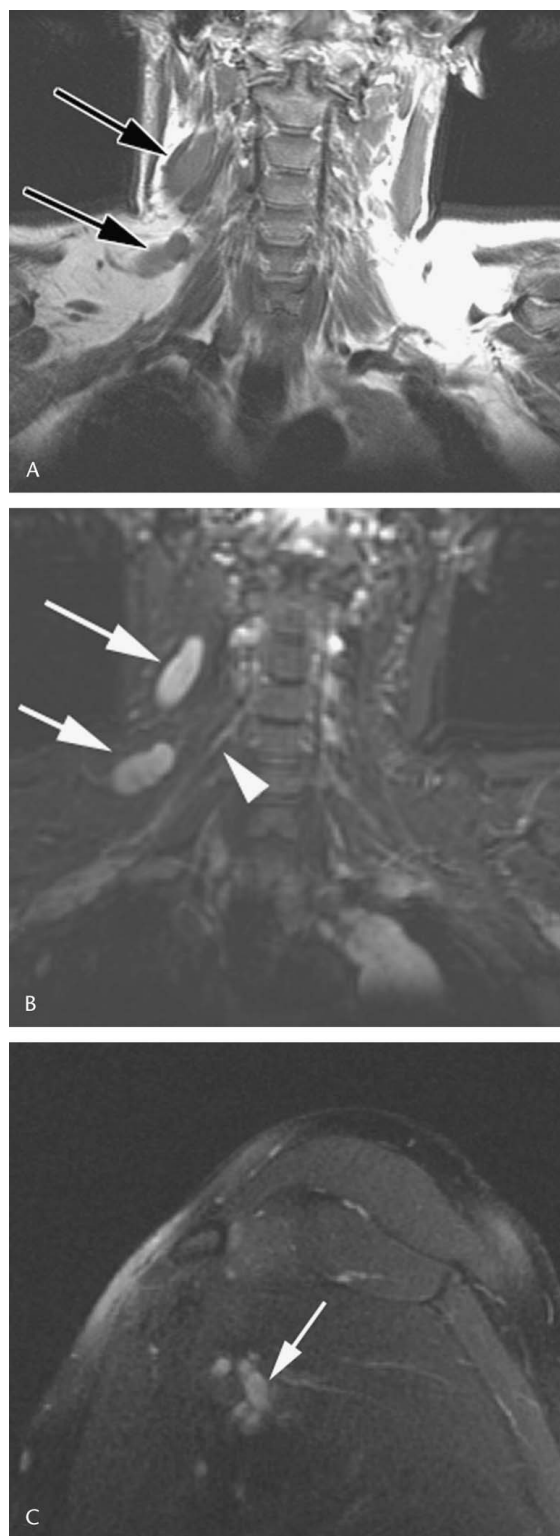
NF-1. A, Coronal T1-weighted image shows enlargement of brachial plexus components. B, Coronal T2-weighted image demonstrating the same (arrows) adjacent to normal nerves (arrowhead). C, Sagittal T2-weighted images demonstrating enlargement of the of the brachial plexus cords.
